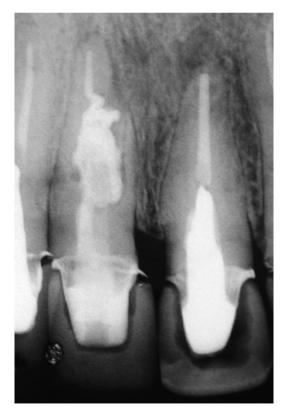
Periapical radiograph of the customized dowel after placement of a new set of provisional crowns.
